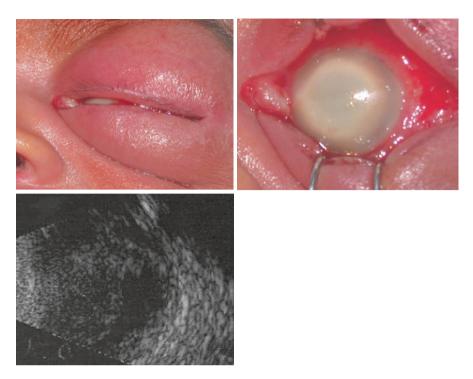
Fulminant gram-negative neonatal endogenous endophthalmitis. Note periorbital edema (*top left*), conjunctival chemosis, corneal edema, and exudates in anterior chamber (*top right*). Ultrasonography shows vitreous echoes, choroidal thickening, and low reflective retinal detachment (*bottom left*)
